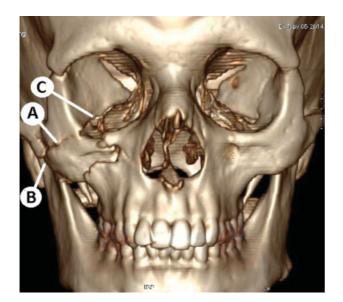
3D CT reconstruction shows: (A) Right tripod fracture with fracture of the right zygomatic arch, orbital floor, and lateral wall of the orbit. (B) Fracture of the coronoid process of right mandibular ramus. (C) Fracture of greater wing of the right sphenoid is seen with fractured fragment causing impingement upon right inferior orbital fissure. (D) Right optic canal and superior orbital fissure is normal.
